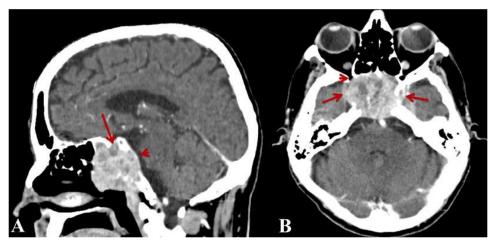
Head contrast-enhanced CT scan (sagittal image) where sella turcica (red arrow) and clivus (red arrow head) are observed (A). Axial contrast-enhanced CT scan where the right orbital apex invasion (red arrow head) and bilateral cavernous sinus invasion (red arrows) are observed (B) (from *Turliuc et al.*, 2016d)
